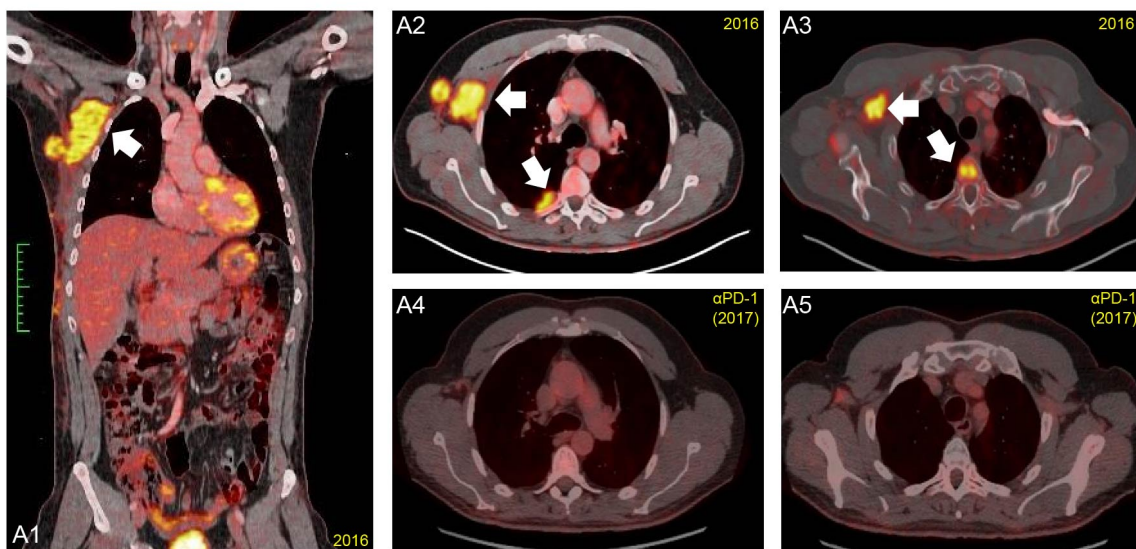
Coronal (left panel) and axial (right panel) images of positron emission tomography with 2-deoxy-2-[fluorine-18] fluoro-D-glucose integrated with computed tomography (18F-FDG PET/CT). A1, A2 and, A3 images depict the lesions before pembrolizumab administration (27/9/2016) by the increased uptake of 18F-FDG in the right axillary lymphoid node and local soft tissue invasion in pleura and osteoblastic spine metastasis. A4 and A5 panels show serial imaging after one year of pembrolizumab administration (27/9/2017) of axial baseline and indicating sustained complete metabolic response and the resolution of the lesions. For A1 to A5, white arrows indicate the localization of the metastatic lesions of melanoma.
